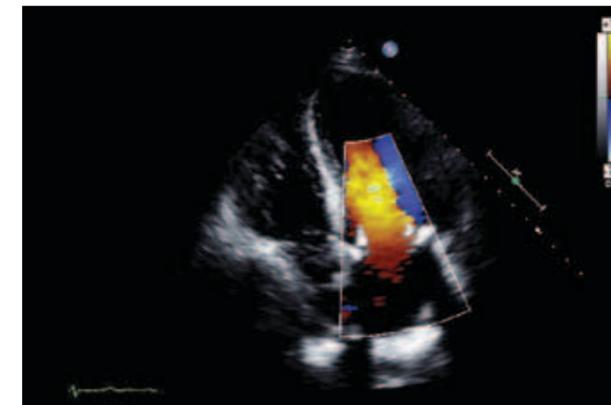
These two images were recorded from two different patients with a stented Xenograft mitral valve replacement (MVR). Images are from the apical 4-chamber view during diastole. Diastolic flow through the MVR on the top image appears laminar; this is consistent with normal transprosthetic flow. Diastolic flow through the MVR on the bottom image appears turbulent; this is consistent with an obstructed MVR.
